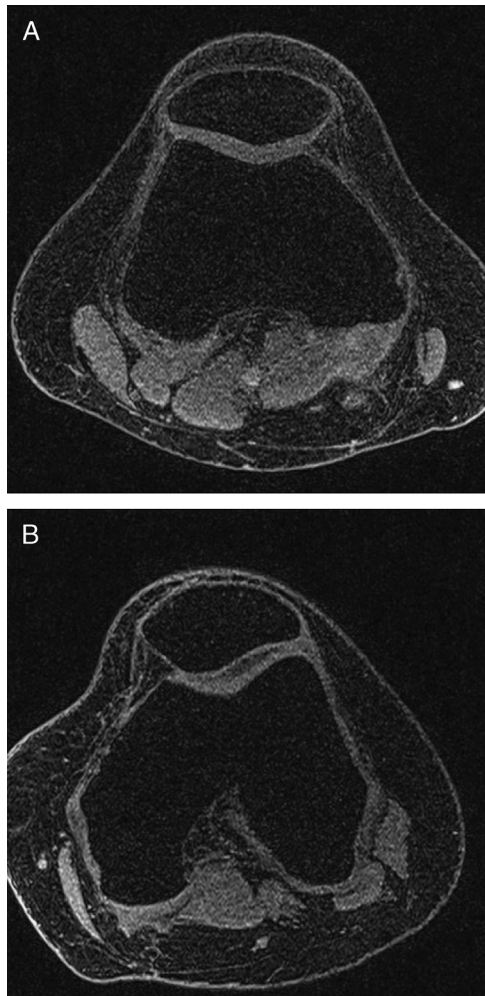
MRI image of patellofemoral joint. A, A typical image from a healthy subject with both the medial and lateral facets touching the femoral condyles in congruent. B, A typical image from a PFPS subject showing the malalignment of patella, with only the lateral facet touching the femoral condyles. MRI indicates magnetic resonance imaging.
